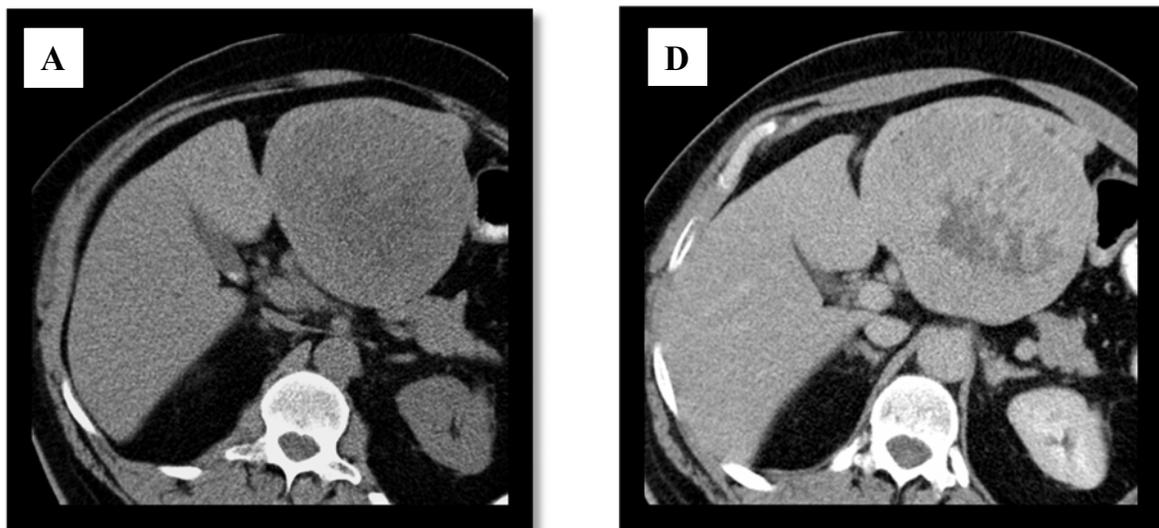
Dynamic Computed Tomography of the liver
